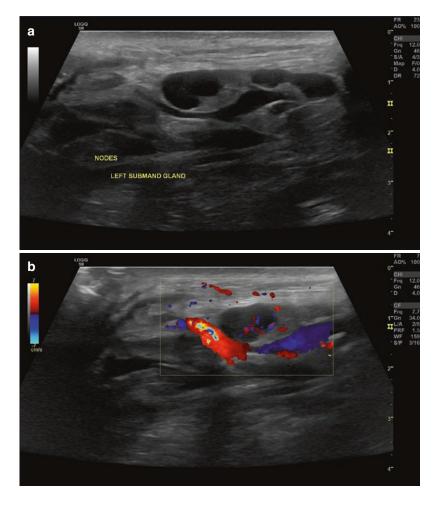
A large lymph node due to inflammation. The node is with ellongated shape and normal texture Fig. 6.5 Inflamed reactive lymph nodes of the submandibular region in patient with a tender, painful and palpable lump. The use of Power and Pulse Wave Doppler demonstrates abnormally enlarged nodes with increased vascularity and benign Resistance Index below 0,72
